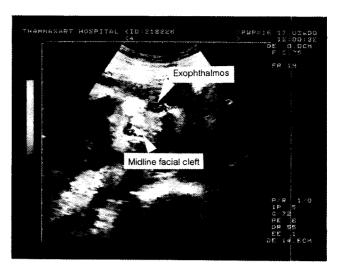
Ultrasound print showing absence of left eye, enlarged right eye, and facial cleft.
